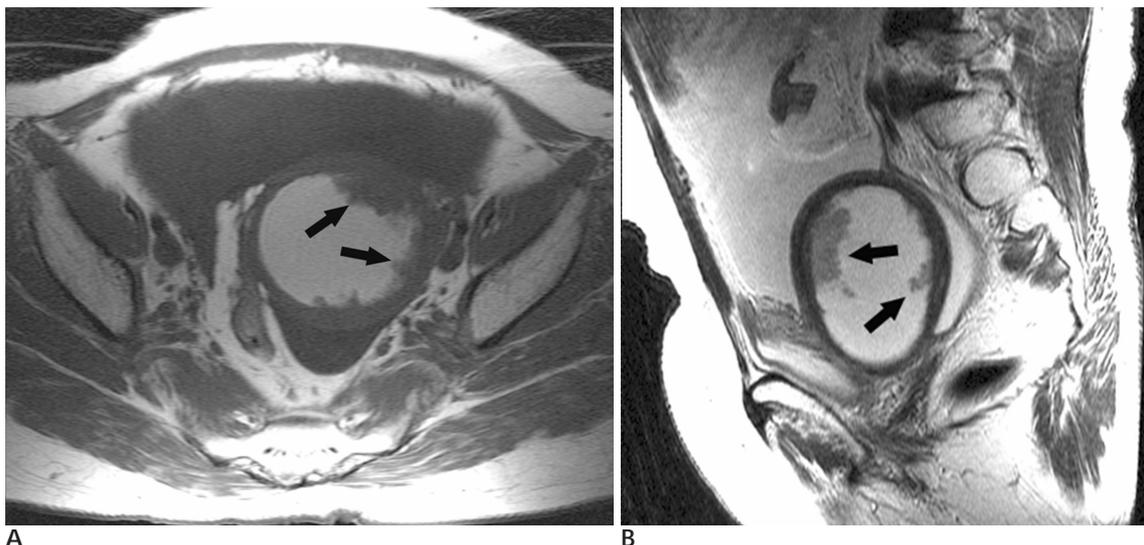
A 48-year-old woman with endometrial cancer 14 years after radiation therapy. A. The axial T1-weighted MR image shows multiple, polypoid isointense masses (arrows) within the distended endometrial cavity. The signal intensity of the fluid within the endometrial cavity is hyperintense, which is suggestive of hematoma. B. The sagittal T2-weighted MR image reveals polypoid, hyperintense masses (arrows) in the markedly distended endometrial cavity.
